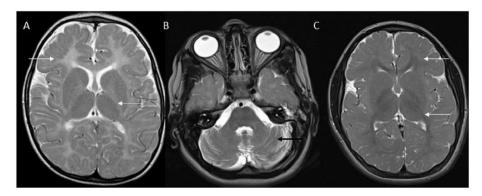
Cerebral Folate deficiency: T2 axial images at 18 months showing marked reduction in myelin for age along with cerebellar atrophy (black arrow in B). Post folinic acid treatment MRI at 5 years shows significant improvement in myelination although still less than expected for age.
